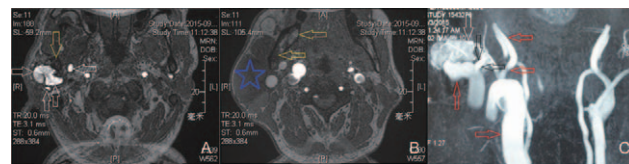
(A, B) Axial sections' projections of magnetic resonance imaging and (C) coronal projection of magnetic resonance imaging angiogram. (A) Some manifold grossus and deformans blood flow signals (white arrow) appearing around the right neck of condyle (yellow arrow) and in the infratemporal fossa. (B) There is an aqueous sac (blue ☆) with a cross section of about 6 × 3.5 cm on the surface of mandible (yellow arrow) and retromandibular triangle region. (C) The right common carotid artery (red “—”), external carotid arterial system are all enlarged, and there is a generous popcorn-shaped cavum (white “!”) directly connecting with the main trunk of superficial temporal artery (red “!”) right next to the root of internal maxillary artery (black arrow). The right internal carotid artery (red “—”) looks normal.
